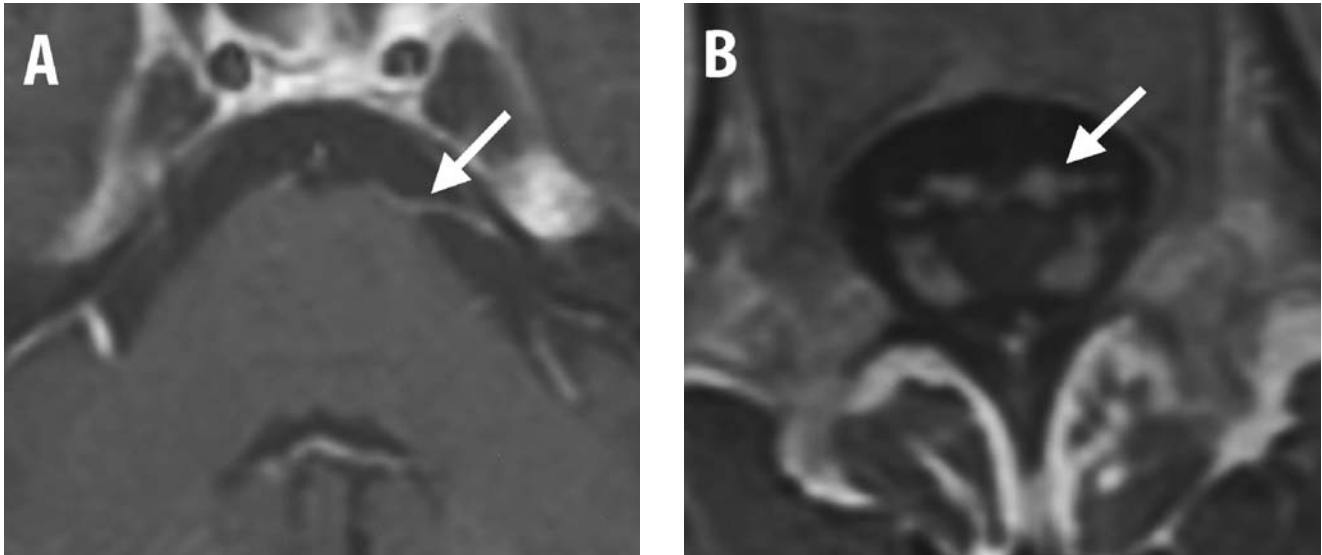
Gadolinium-enhanced T1-weighted MRI showing massive meningeal contrast enhancement (flashes) along cranial (A) and lumbar spinal (B) nerve roots
